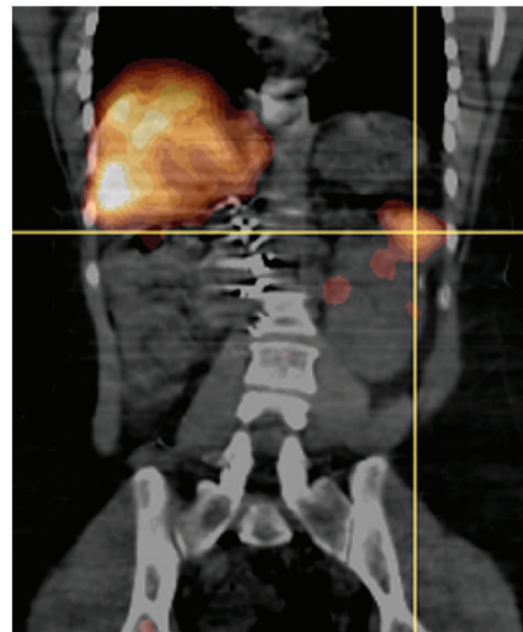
Coronal reformat SPECT/CT image from Tc-99 m-labeled heat damaged red blood cell scintigraphy – expected accumulation of activity in the liver and bone marrow. The spleen and right kidney are absent. There is focal accumulation of tagged red blood cells in the upper pole of the left kidney corresponding to the the mass identified on CT and ultrasound.
